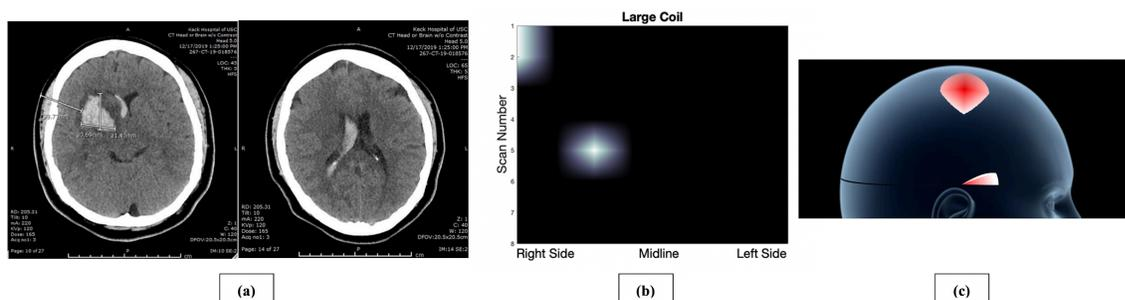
a) CT imaging showing a right basal ganglia ICH and associated IVH. b) Two-dimensional data gathered from the ECD sensor. Of note, the Large Coil has the largest magnetic field depth, and thus was able to detect both hemorrhages. c) Three-dimensional projections of each coil. 3D graphics can be created in real-time to rapidly guide clinical judgement and reduce time-to-treatment.
